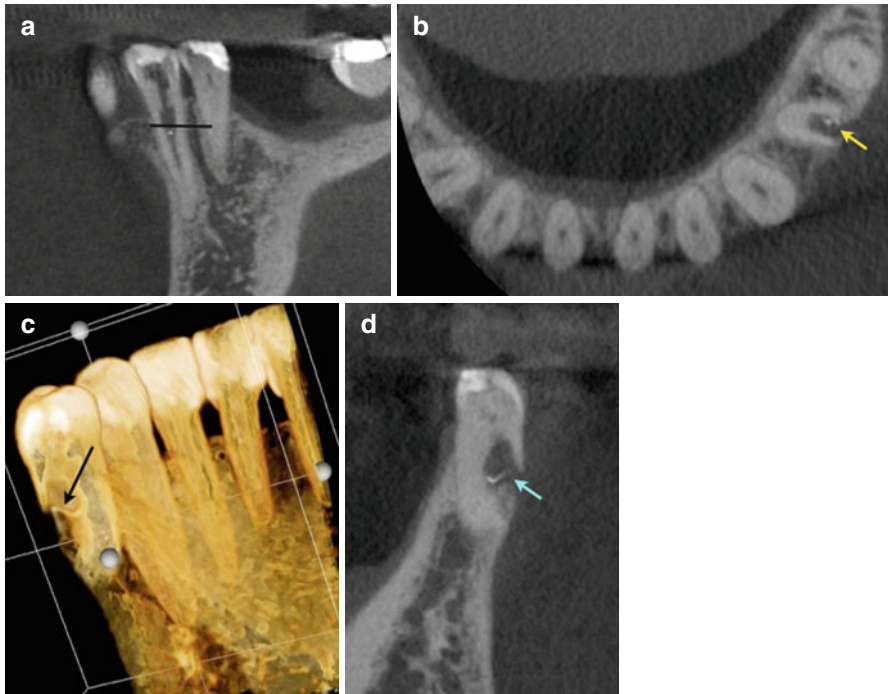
(a) Periapical radiograph of tooth #21. The patient was referred for evaluation and treatment of an internal resorptive defect. The line corresponds to the axial section view in (b). (b) Axial view demonstrating the ICR nature of the defect (*yellow arrow*). (c) 3D reconstruction of the resorptive defect (*black arrow*). (d) Coronal view of tooth #21 demonstrating the external/internal resorptive defect (*blue arrow*). Note in (b, c, and d) the perforated root on the buccal aspect renders tooth #21 non-restorable. The treatment plan changed after reviewing the CBCT images
